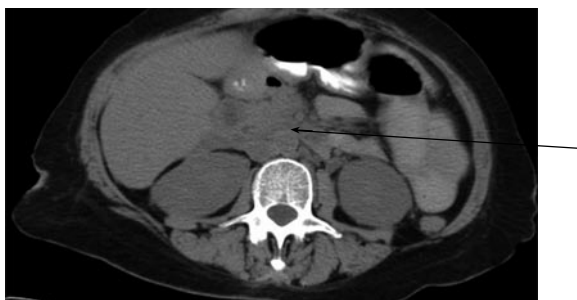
CT of abdomen showing retroperitoneal fibrosis, encasing aorta and inferior vena cava.
